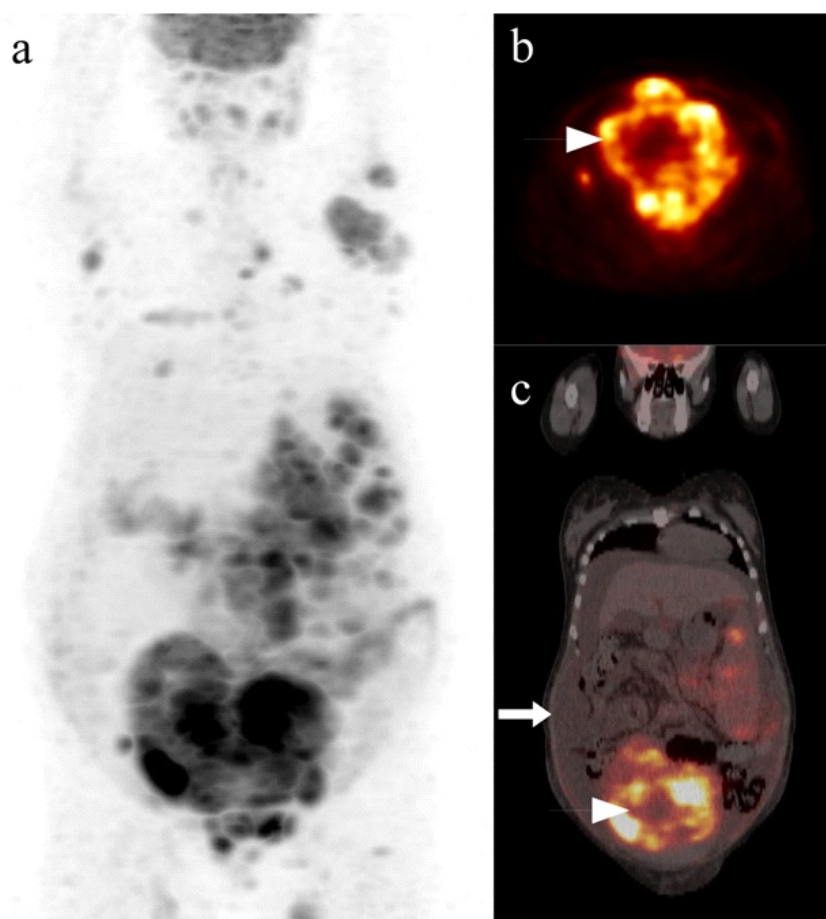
A 35-year-old woman with DHL presented with multiple lesions involving a large abdominal mass accompanied by significant ascites, as demonstrated on the coronal maximum intensity projection (MIP) ^{18}F -FDG PET image (a). The coronal ^{18}F -FDG PET image (b) reveals a region of hypometabolism within the hypermetabolic mass, indicative of necrotic tissue (arrows). The fused coronal ^{18}F -FDG PET/CT (c) images further clarify the presence of necrotic areas within the abdominal tumor masses (white arrowheads) and ascites (white arrows). The patient subsequently received 6 cycles of dose-adjusted etoposide, prednisolone, vincristine, cyclophosphamide, doxorubicin, and rituximab (DA-EPOCH-R) chemotherapy and experienced recurrence at 11 months, followed by death at 18 months.
